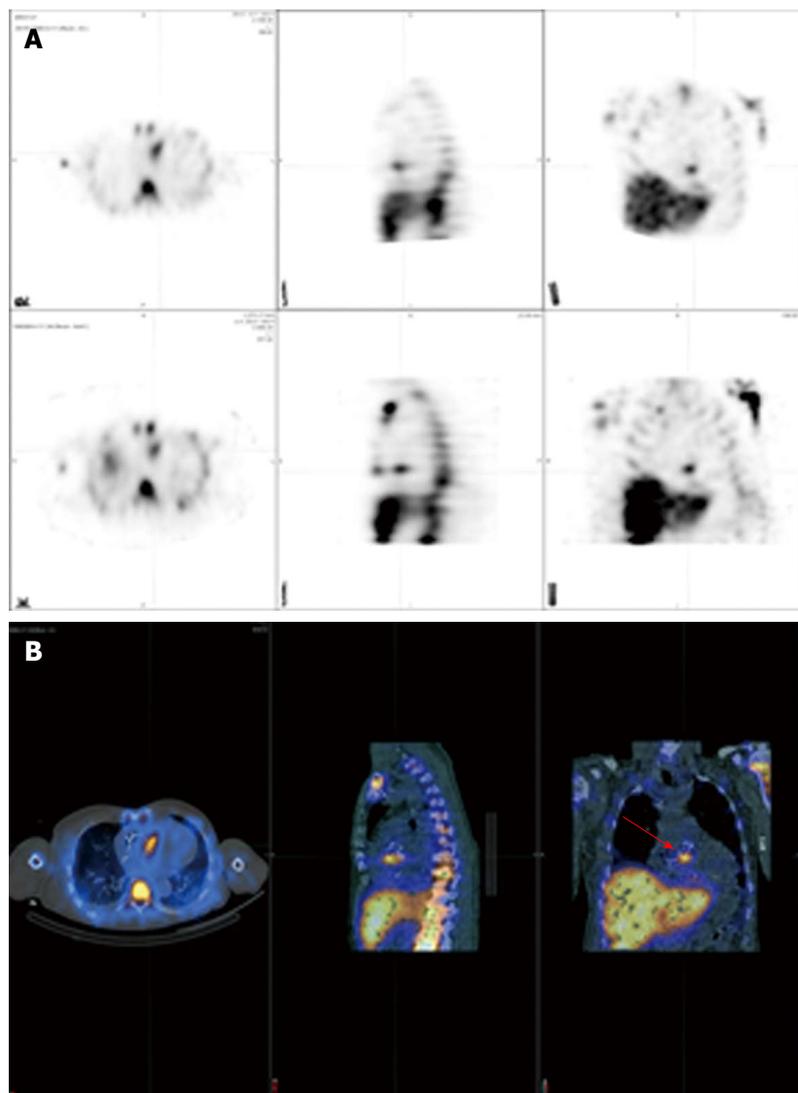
Positive ^{111}In white blood cell single-photon emission computed tomography/computed tomography in a patient with endocarditis following an aortic valve replacement (red arrow). A: SPECT displayed as transverse, sagittal, and coronal attenuation corrected (top row) and uncorrected images (bottom row); B: Hybrid SPECT/CT displayed as transverse, sagittal, and coronal images. SPECT/CT: Single-photon emission computed tomography/computed tomography.
